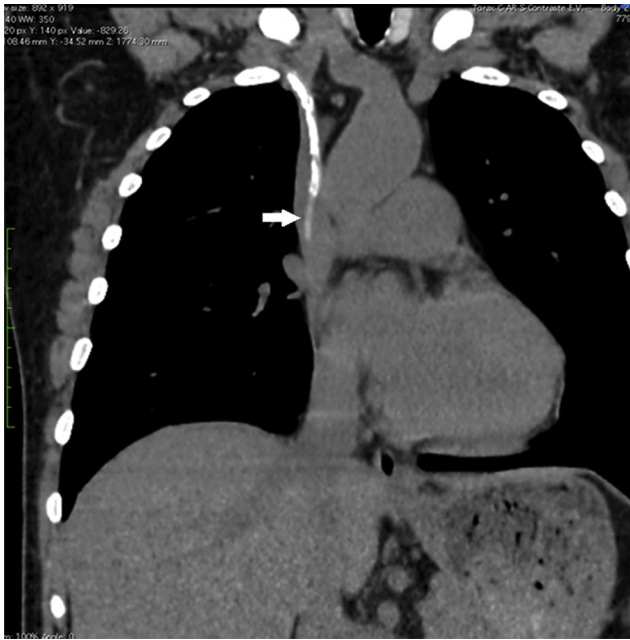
Computed tomography showing a foreign body (arrow) in the right subclavian vein and superior vena cava that was retained after percutaneous lead extraction.
